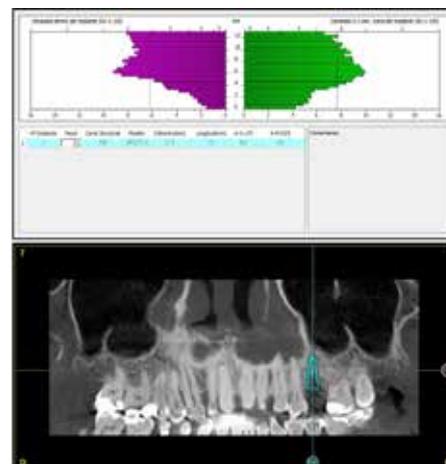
Planning Cone Beam
